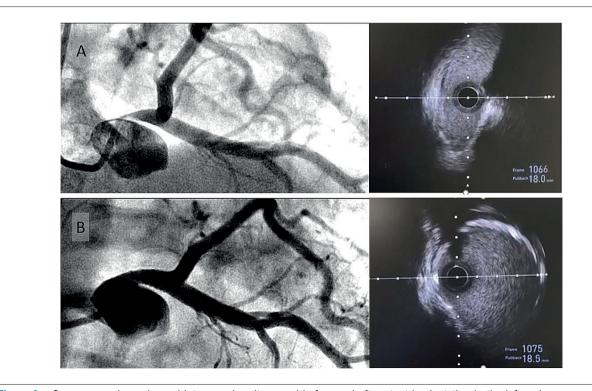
Coronary angiography and intravascular ultrasound before and after stent implantation in the left main coronary artery (patient 5). In the baseline assessment (A), marked luminal narrowing is observed both on coronary angiography (left) and intravascular ultrasound (right), showing a slit-like lumen without evidence of atherosclerotic plaque. After stent implantation (B), restoration of vessel lumen dimensions and symmetry is noted.
